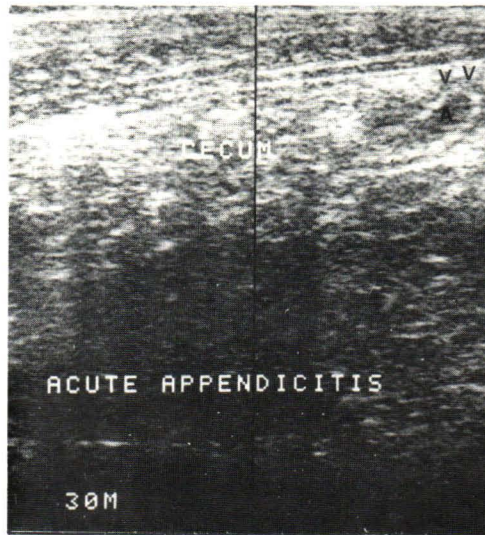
Sonographic landmarks of the appendix
